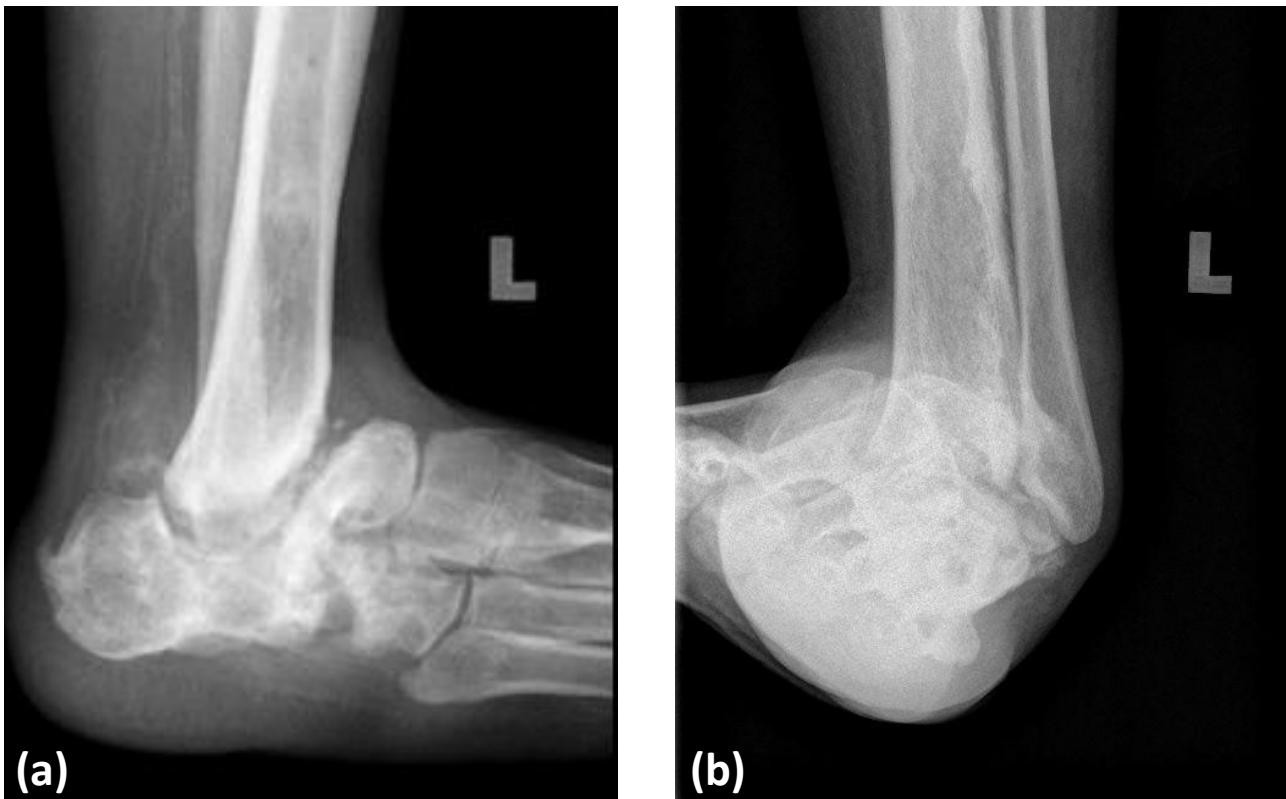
(a) Lateral view and (b) AP view of plain radiographs of the ankle show bony destruction and osteolysis of the talus and the surrounding structures causing hindfoot and midfoot deformity
